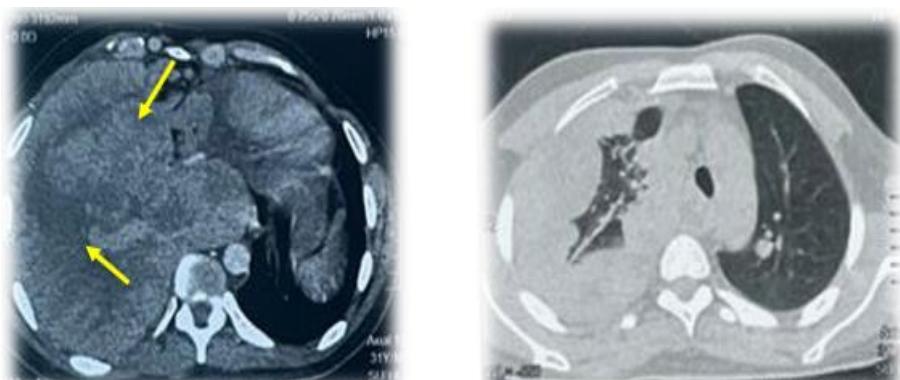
Chest CT Scan Shows Pleural Masses Encasing the Right Lung and Bilateral Pulmonary Parenchymal Nodules, Predominantly on the Left Side.
